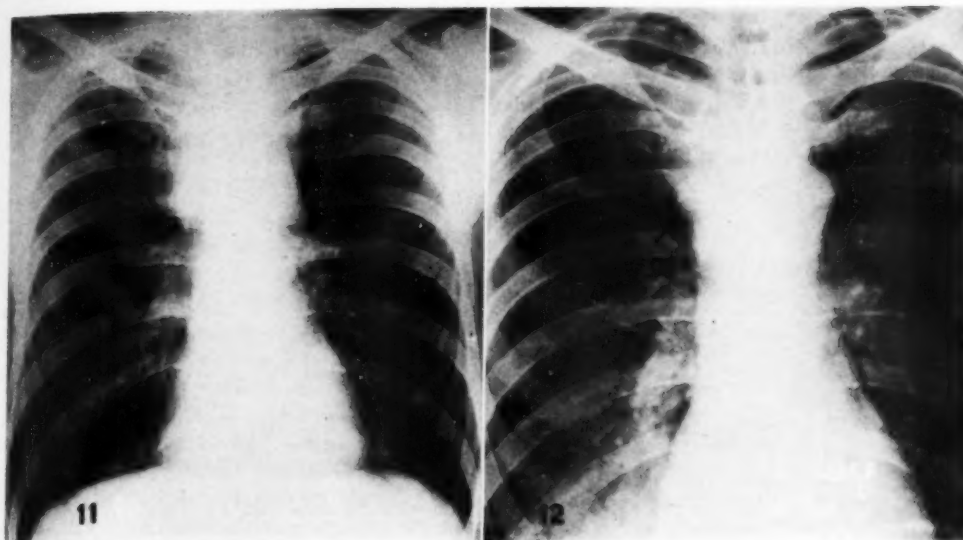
Appearance of the chest at the completion of therapy; 2,622 r had been delivered to the tumor in a period of thirty-five days. The roentgenogram appears normal.
